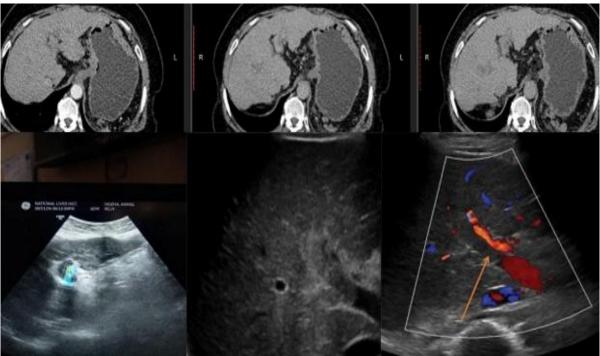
Benign PVT by CT and US-SWE
